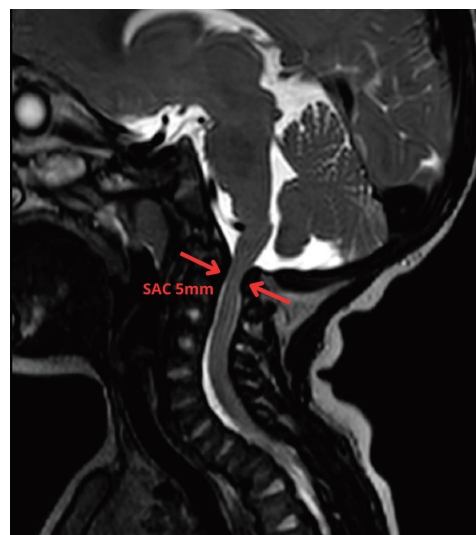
Pre-traumatic sagittal T2-weighted magnetic resonance image demonstrating severe atlantoaxial stenosis with complete effacement of the cerebrospinal fluid space surrounding the spinal cord. The space available for the cord (SAC) measured 5 mm and was determined as the shortest distance between the posterior margin of the anterior soft tissue/odontoid complex and the anterior surface of the posterior arch of C1 (red arrows).
